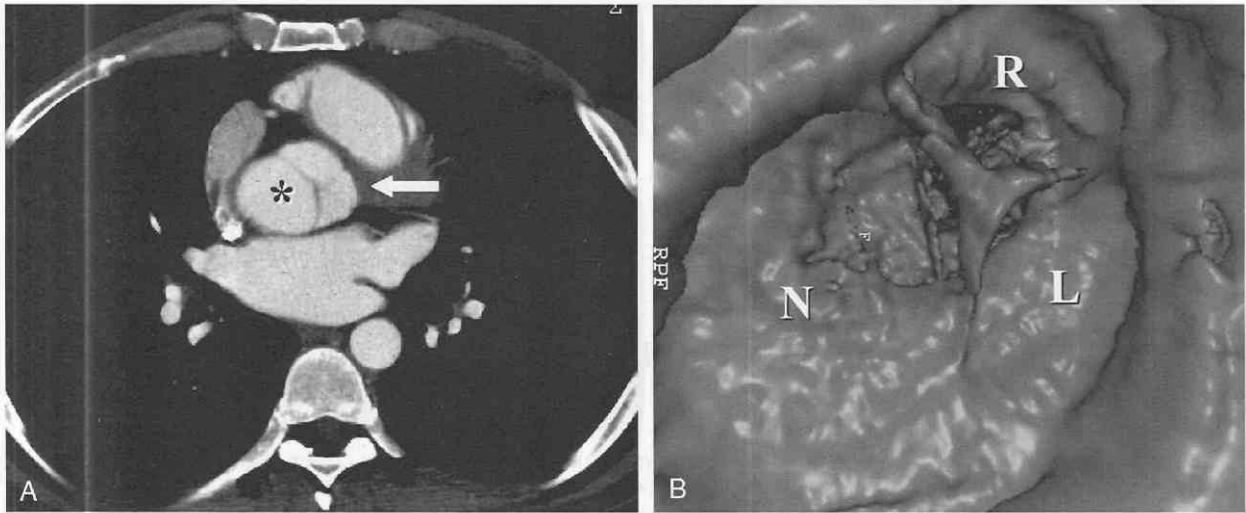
A, Axial CT scan in a young man in whom a chest radiograph showed an aortic prominence. Note the enlarged aortic root (arrow) with asymmetrical enlargement of the noncoronary cusp (*). B, Virtual endoscopic image shows normal appearance of the left (L) and right (R) coronary cusps and asymmetrical enlargement of the noncoronary cusp (N).
